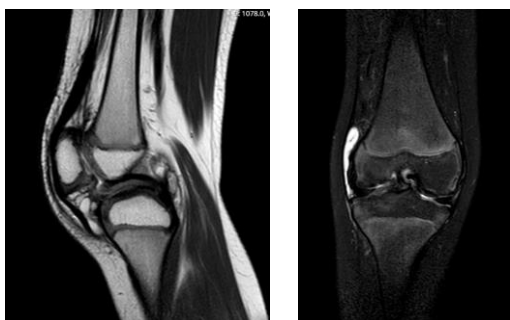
(A) Postoperative MRI T1-weighted sagittal sequences (B) T2-weighted coronal sequences with 18 months followed-up: decrease in area of lesion and contrasting of synovium
